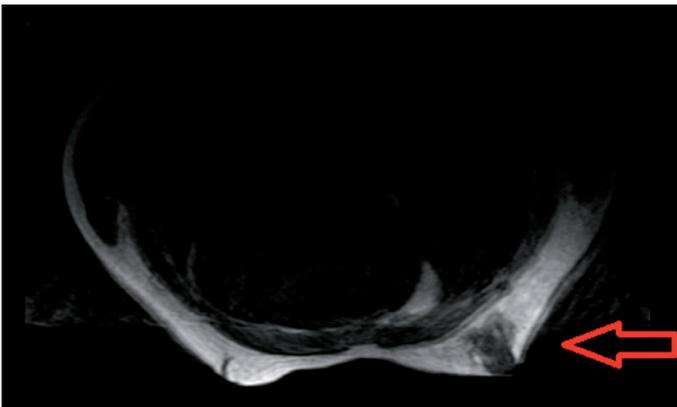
Contrast-enhanced fat-saturated T1-weighted axial images demonstrate subareolar asymmetric fibroglandular tissue proliferation in the right breast. The enhancement is slow, persistent and non-mass like. This finding is consistent with unilateral gynecomastia.
